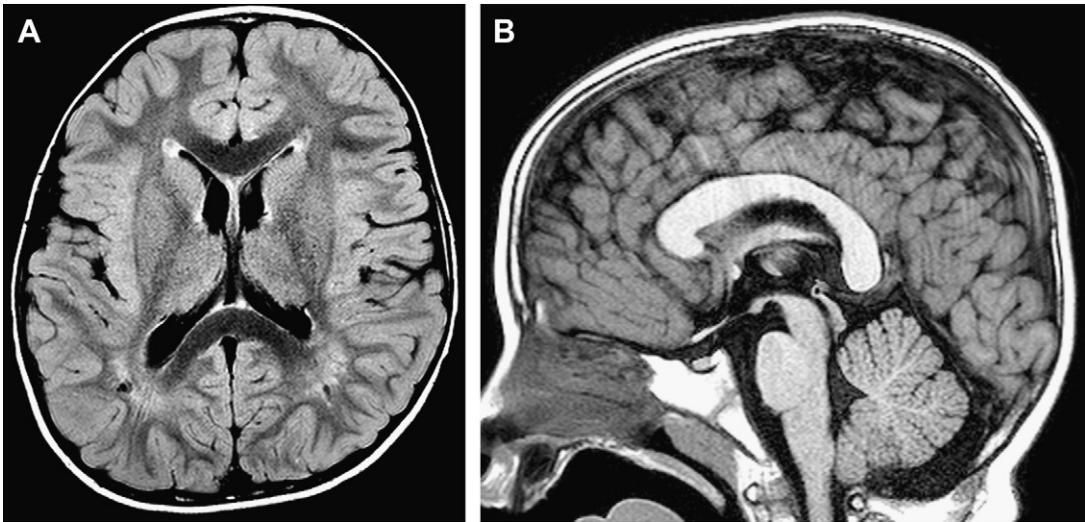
Primary macrocephaly (Sotos syndrome). (A) Axial FLAIR. Large head, large slightly asymmetric hemispheres, prominent ventricles. Some gliotic/cystic changes in the deep posterior white matter are nonspecific. (B) Midline sagittal T1 demonstrates a thick corpus callosum (bulky white matter).
